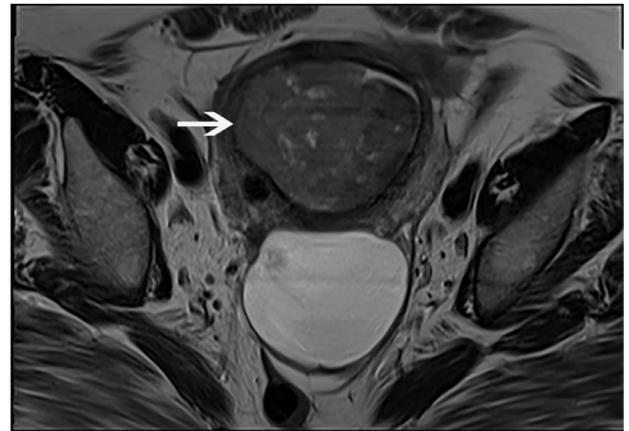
Axial, T2-weighted MRI image shows the UCS (white arrow) as a heterogeneous mass with internal areas of cystic necrosis expanding the endometrial cavity. UCS, uterine carcinosarcoma.
